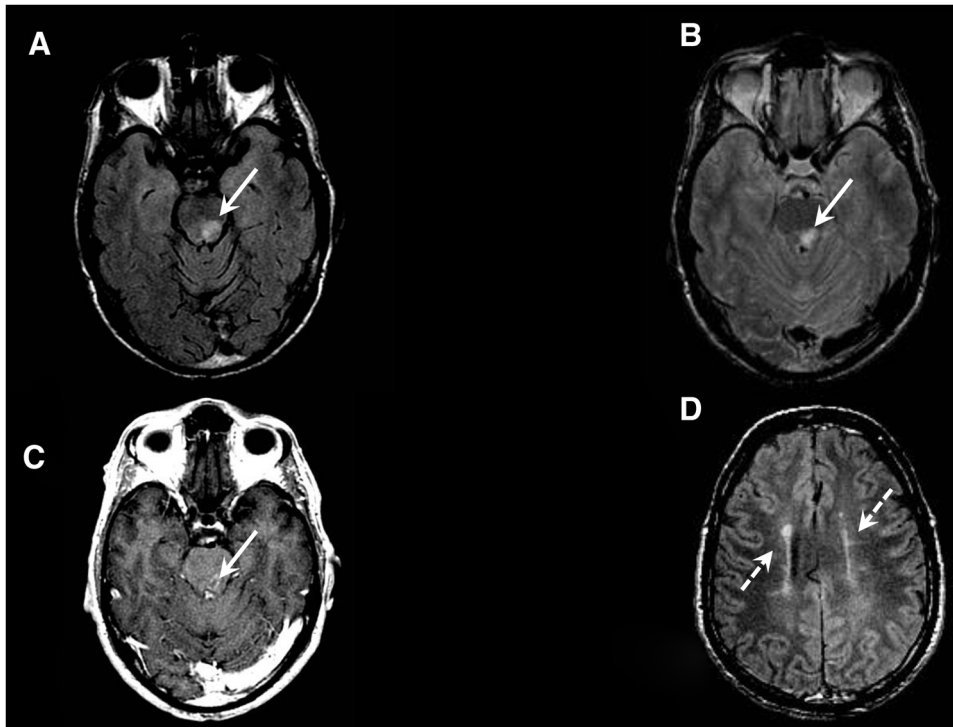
Brain MRI scan (axial plane). A and B) FSE T2-FLAIR and FSE T2 sequences at the level of the orbital apex showing a focal lesion to the left posterior parasagittal region of the pons (solid arrows). C) 3D FSPGR T1 sequence after intravenous administration of single-dose contrast, revealing open ring contrast enhancement around the lesion (solid arrow); this is a frequent finding in inflammatory/demyelinating lesions. D) FSE T2 FLAIR sequence showing more than 3 lesions to the supratentorial periventricular white matter, distributed along an axis perpendicular to the lateral ventricles; these findings are also frequent in patients with inflammatory/demyelinating lesions (dashed arrows).
